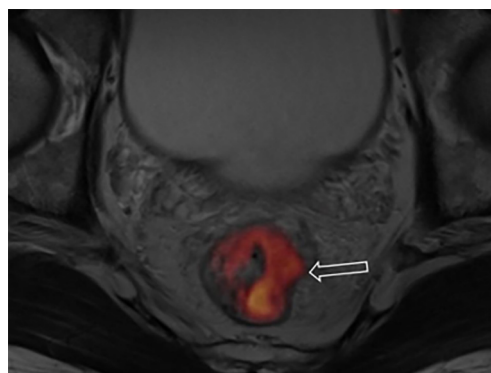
A 55-year-old man with low RC. Fused axial MR rectography and DWI shows a stage T3a tumor (arrow) in hot color which has broken through the outer membrane of the rectum. RC, rectal cancer; DWI, diffusion weighted imaging.
